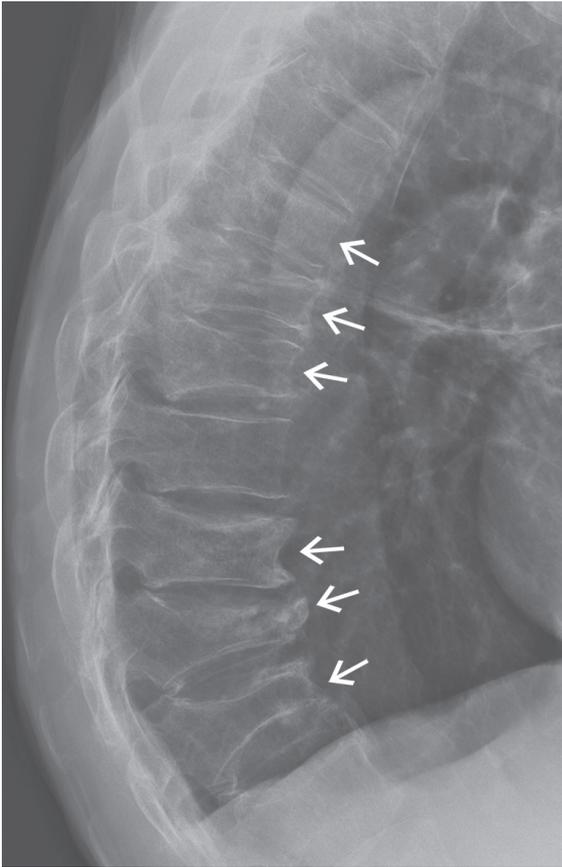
Lateral radiograph showing vertebral fracture cascade with fractures of many contiguous or near-contiguous vertebrae. *With kind permission of Quantitative Imaging in Medicine and Surgery.*⁽¹¹⁹⁾
